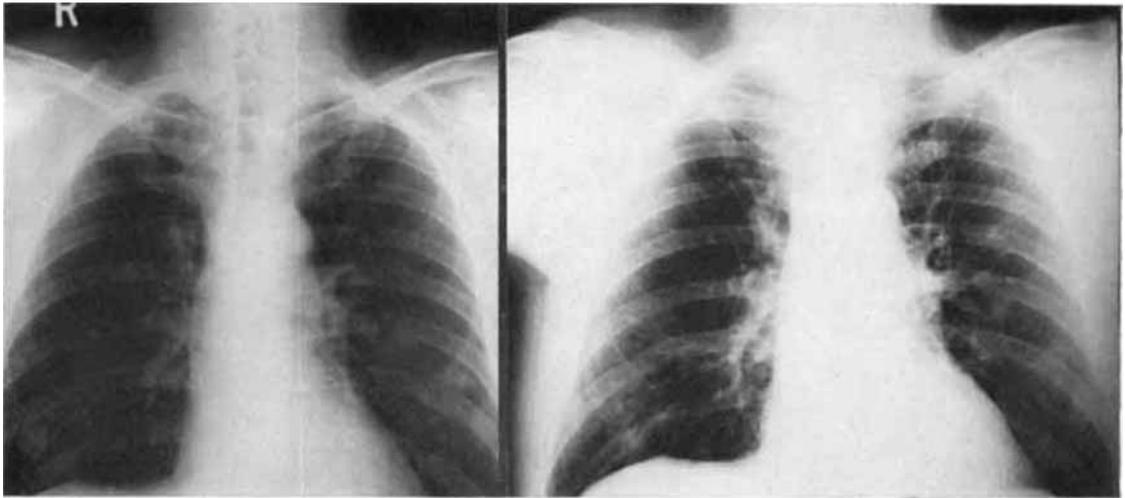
A (left), Chest roentgenogram of patient GB after 3 months of no response to medroxyprogesterone acetate. B (right), Almost complete response to testosterone propionate.
